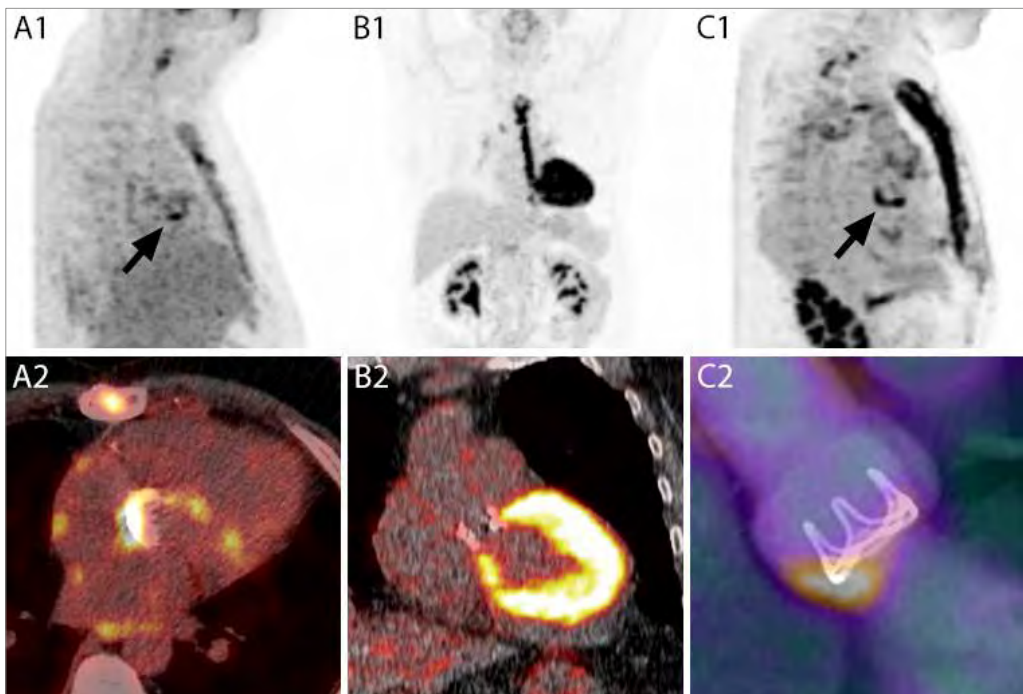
Positron emission tomography maximum intensity projections (A1, B1, C1) and fused positron emission/computed tomography (A2, B2), or positron emission tomography/computed tomography angiography (C2) images of false positive positron emission tomography scans due to recent valve implantation of a mechanical aortic valve (27 days prior to positron emission/computed tomography imaging) (A, arrow); inadequate suppression of myocardial ^{18}F -fluorodeoxyglucose uptake in a patient who did not adhere to the dietary instructions, making assessment of the perivalvular area of this mechanical aortic valve nearly impossible (B); and prior use of certain fluorodeoxyglucose-avid surgical adhesives in this patient who underwent a Bentall procedure with biological aortic valve prosthesis 3 years prior to positron emission tomography imaging, during which BioGlue (CryoLife Inc., Kennesaw, GA, USA) had been applied in a small area of the artificial annulus (C, arrow).
